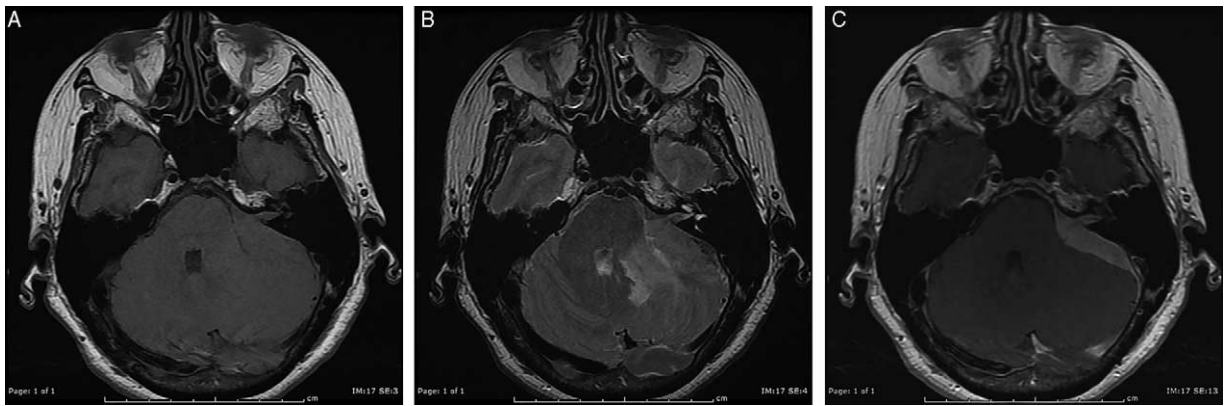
Preoperative brain MRI axial images. *A*, T1-WI demonstrates an isointense to gray matter signal—intense dural-based mass at the left CPA extending into and filling the internal auditory canal. The mass exerts a mild degree of mass effect on the brachium pontis. *B*, Fast spin echo T2-WI demonstrates the mass to be isointense (note the hyperintense signal within the brachium pontis and the deep white matter of the cerebellum, which may represent edema). *C*, Postcontrast T1-WI shows homogeneous avid enhancement mass that appears to rise from and follow the dura along the CPA extending into the IAC. CPA indicates cerebellopontine angle; IAC, internal auditory canal; MRI, magnetic resonance imaging; WI, weighted image.
